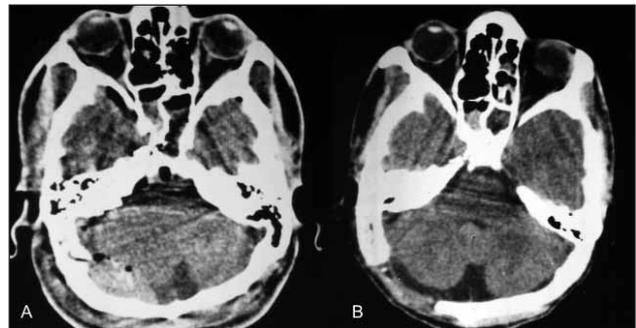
A: Axial CT scan demonstrating epidural hematoma over right suboccipital area exerting a mass affect on right cerebellum. B: Follow-up CT scan showed complete removal after suboccipital craniectomy.
